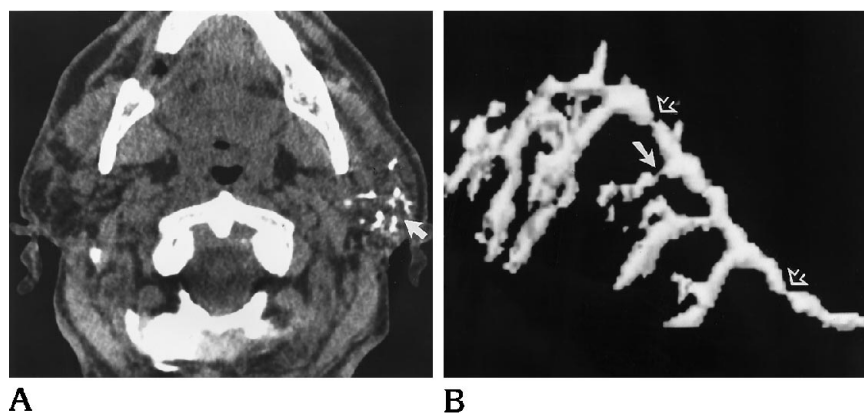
Chronic recurrent left parotid sialadenitis. A, Axial conventional CT scan after sialogram shows punctate accumulation of contrast material within presumed dilated intraparotid ducts (arrow). B, Three-dimensional CT sialogram (lateral view, left ductal system) shows focal areas of narrowing and prestenotic dilatation of both main (open arrows) and accessory ducts (closed arrow).
